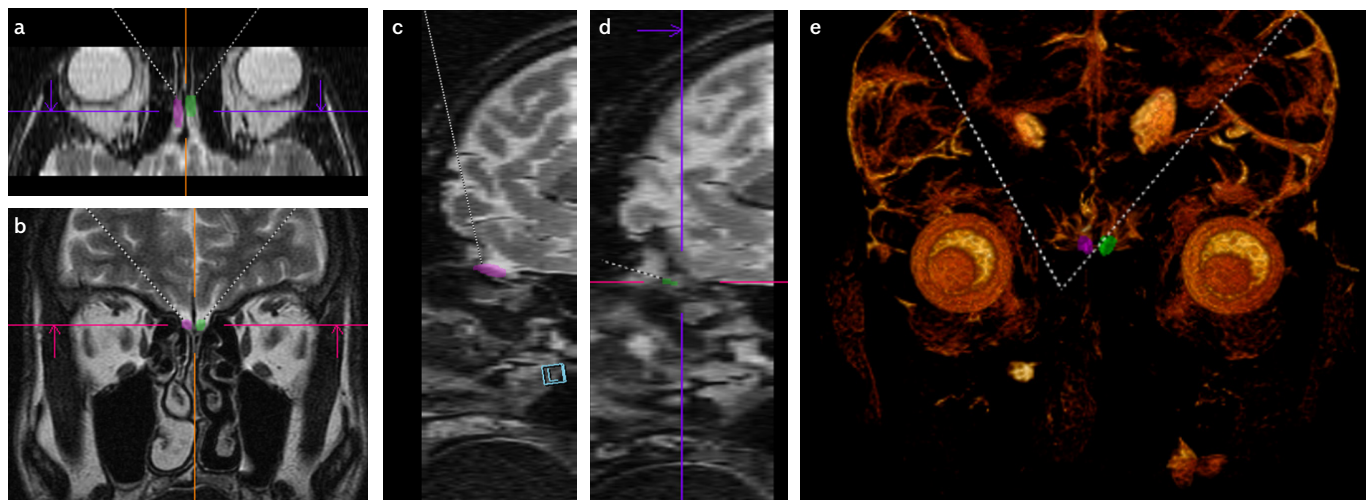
a-e. Right and left olfactory bulb volume (OBV) T2-weighted magnetic resonance (MR) sections and volume rendering technique (VRT) MR images of a patient with diabetic olfactopathy. In this patient, OBV measurements are 62 mm³ on the right and 69 mm³ on the left:
